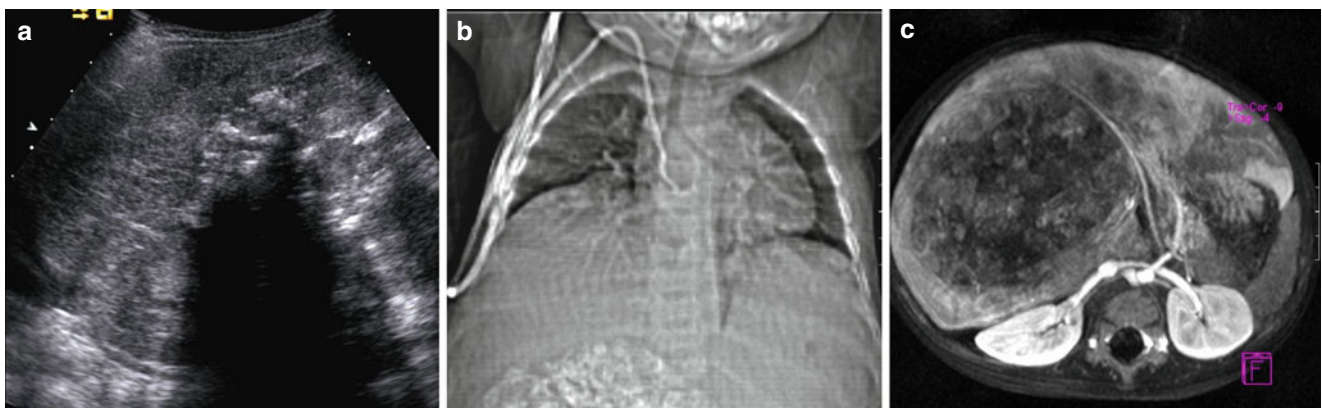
Hepatoblastoma. (a) Ultrasound shows a large mass with echogenic foci representing calcification which is typical of hepatoblastoma. (b) Topogram from the CT shows the liver mass to be elevating
